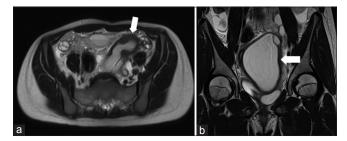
Pelvic magnetic resonance imaging. (a) A high-resolution, T2-weighted sequence in the axial plane shows hematometrocolpos in the left hemiuterus (white arrow). (b) Coronal plane shows a large cystic mass (white arrow)
